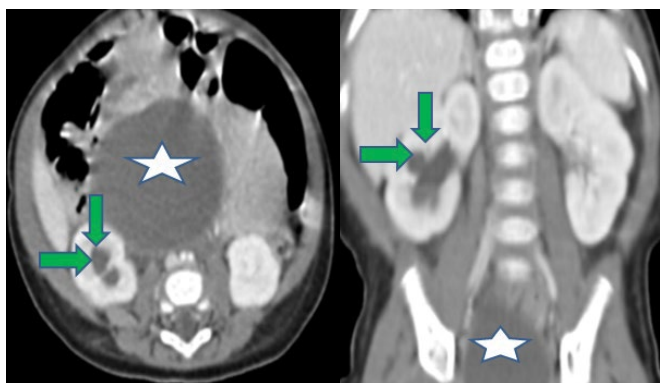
Axial and coronal CT images of abdomen show mild right-sided hydronephrosis (green arrows) due to compression by a large distended uterine cavity.
